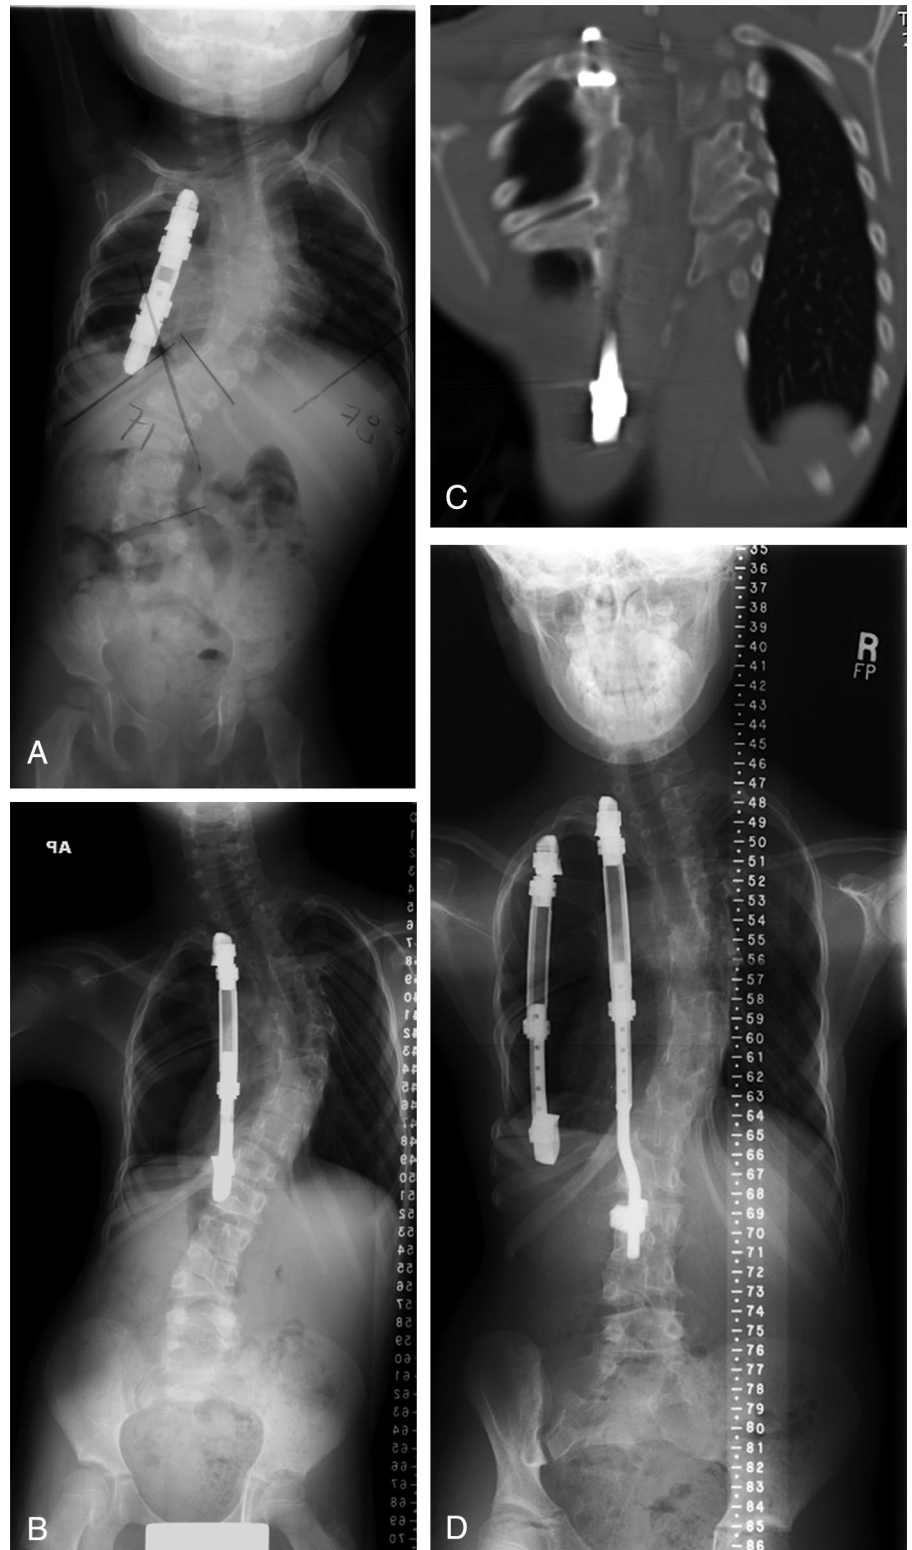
Recurrent rib fusion. This patient had been treated for congenital rib fusions and congenital scoliosis with expansion thoracostomy and insertion of VEPTR devices at age 13 months (A). At age 8 (B), periodic device lengthening became difficult and CT (C) revealed extensive recurrent rib fusions beneath the VEPTR device. Revision with resection of rib fusions and repeat expansion thoracostomy regained control of chest and spine deformity and has continued to withstand repeated lengthening though 4 years (D) follow-up. When lengthening of VEPTR devices becomes difficult, CT may reveal underlying rib fusions which may be amenable to repeat expansion thoracostomy.
